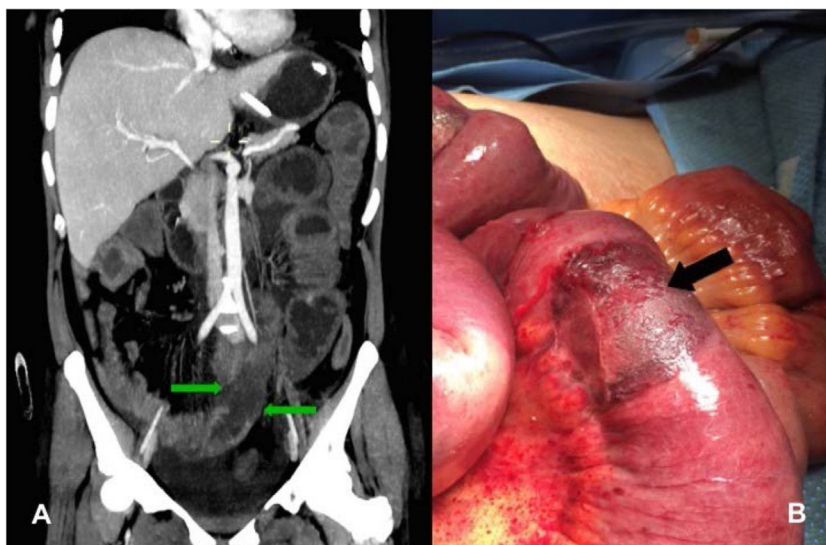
A) Computed tomography scan of the stomach showing segmental areas of hypoperfusion of the intestinal wall (green arrows). B) Intraoperative image with numerous well-limited, circumferential, ischemic zones in the small bowel (black arrow).
